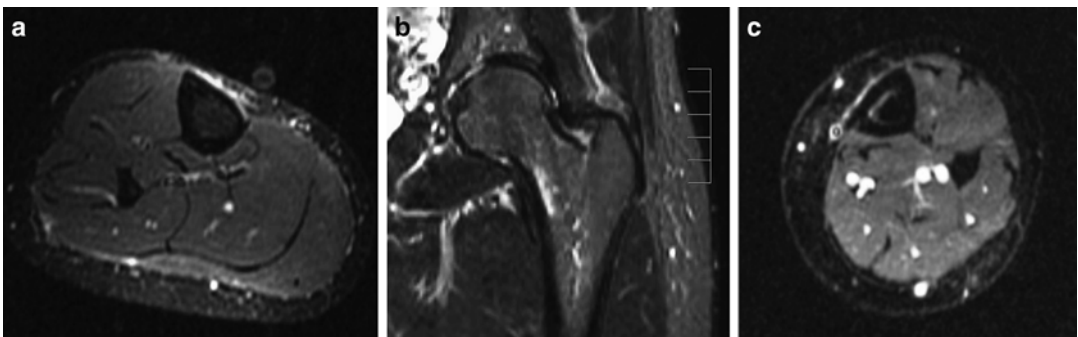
Different stress responses on MR imaging. Fluid-sensitive MR images in three different athletes. (a) Periostitis along the medial cortex of the tibia manifests as linear high-signal intensity along the outer cortex.
